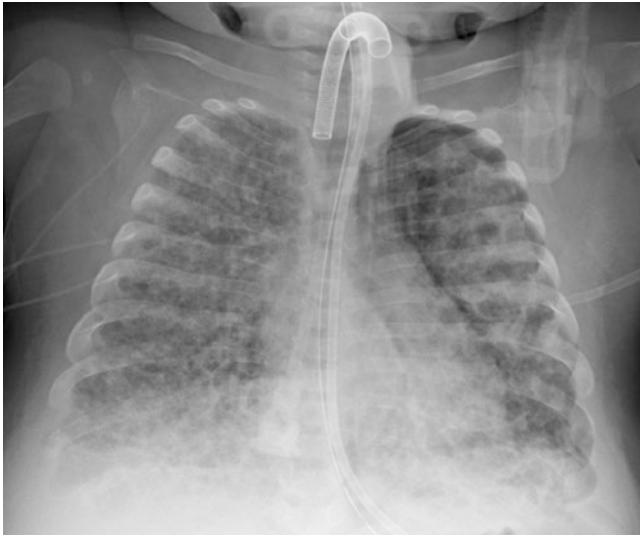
An 8-month-old boy with history of prematurity and chronic lung disease of prematurity. Frontal chest radiograph shows coarse opacities and hyperinflation of both lungs in keeping with chronic lung disease of prematurity. Left-sided pneumothorax is also seen. In addition, tracheostomy, nasogastric tube, and feeding tube are seen
